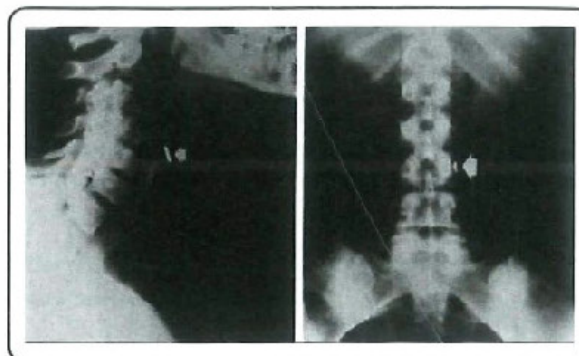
Radiograph showing an aspirated instrument
